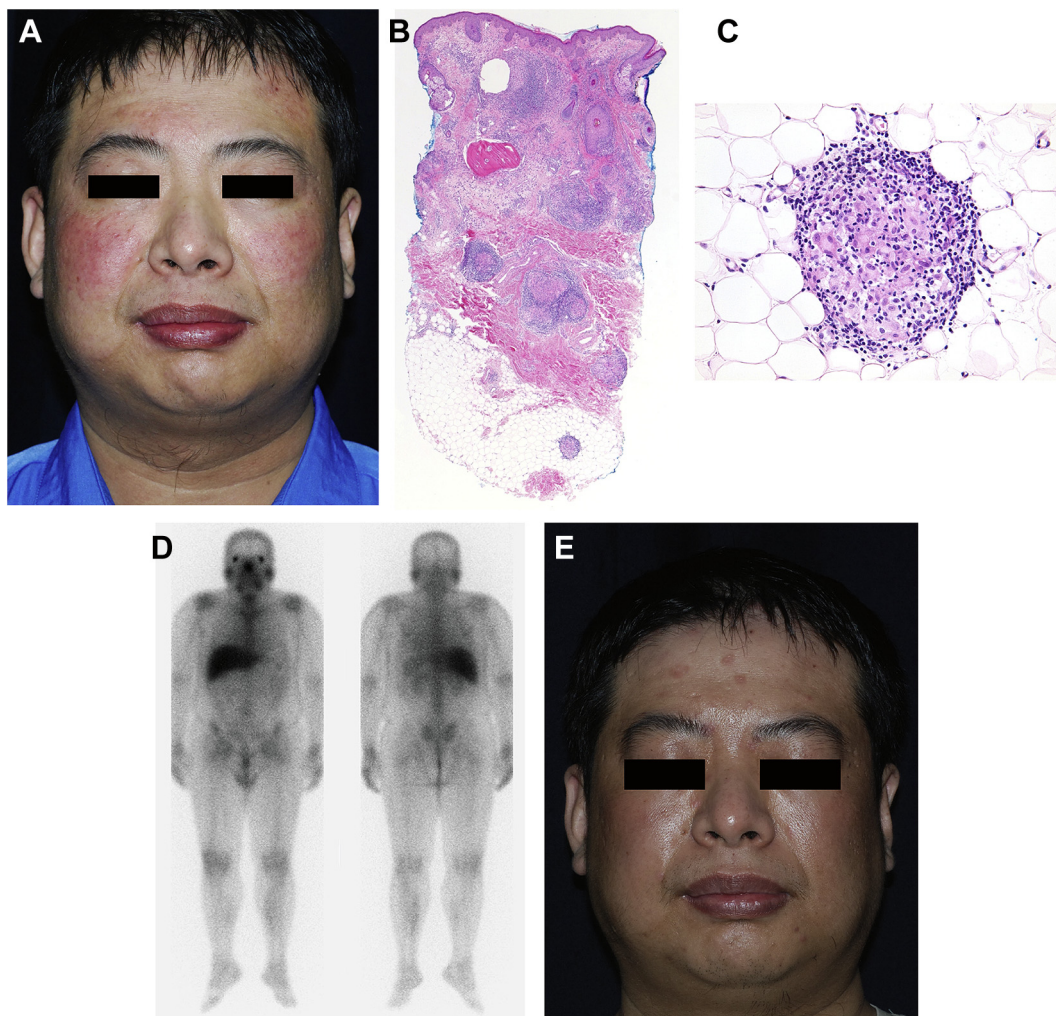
(A) Various-sized reddish papules distributed within ill-defined erythematous infiltrative plaques over bilateral cheeks of the patient. (B) Multiple foci of well-formed granulomas composed of aggregate of epithelioid histiocytes and with prominent surrounded lymphocytes in the dermis and included subcutis. (C) High-powered view of subcutis lesion: aggregation of epithelioid histiocytes within clear background and few surrounded lymphocytes, indicating a naked granuloma. (D) Symmetrically increased gallium tracer uptake at lacrimal and salivary glands (panda sign) in gallium-67 whole body inflammation survey with regional single photon emission computed tomography. (E) Complete resolution of facial skin lesions after 2 months of discontinuation of adalimumab.
